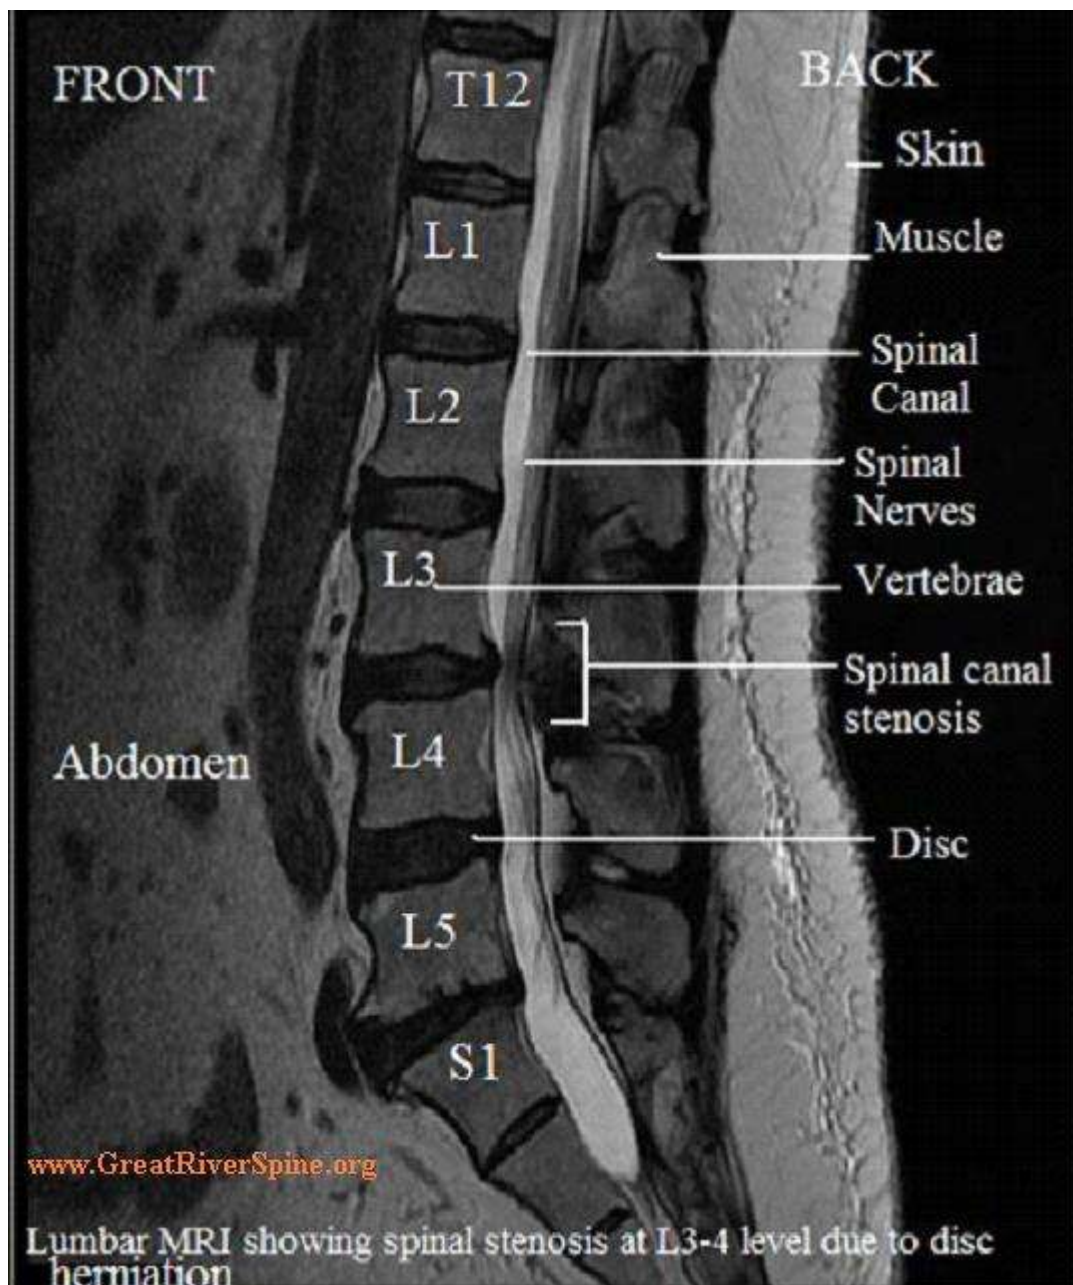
MRI showing lumbar canal stenosis
